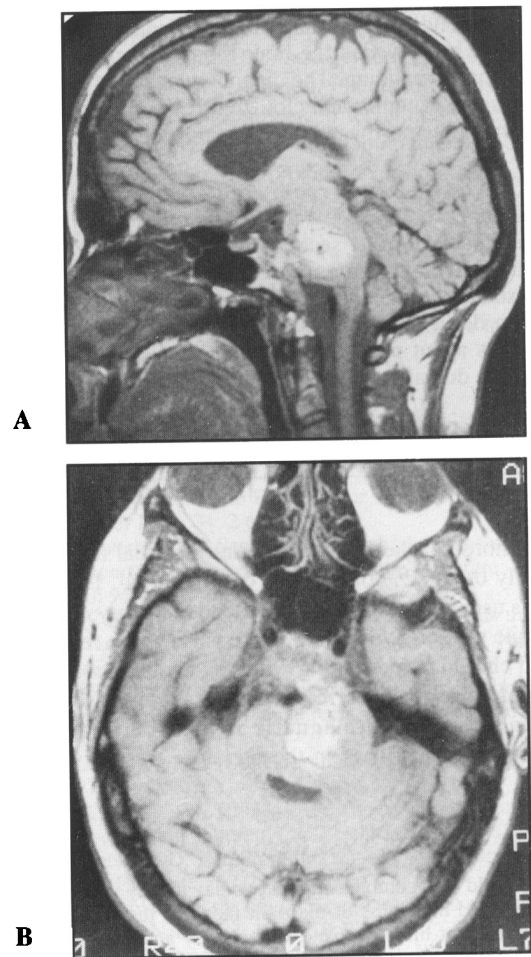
T1-Weighted MRI (SE 600/20). (A) Sagittal image 5 mm to the left of midline. The normal marrow fat of the clivus has been replaced by tumor extending from the anterior lip of the foramen magnum to almost the sellar floor. A large exophytic portion of the tumor extends through the prepontine cistern into the substance of the pons. The entire brain stem is displaced dorsally. The hyperintensity of the T1-weighted MRI together with the hyperdensity on unenhanced CT indicates the presence of hemorrhage in the pontine component of the tumor. (B) Axial image through the pons. The intra-clival, intracisternal and intra-axial components of the tumor are all demonstrated on this image. There appears to be a plane separating the tumor from the brain stem (arrows).
